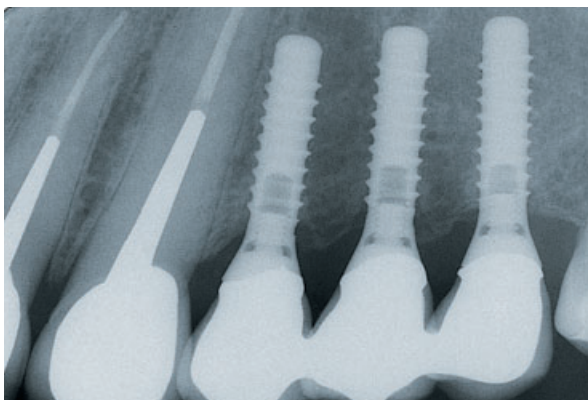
On the 1-year follow-up radiograph an acceptable marginal fidelity can be assessed.
